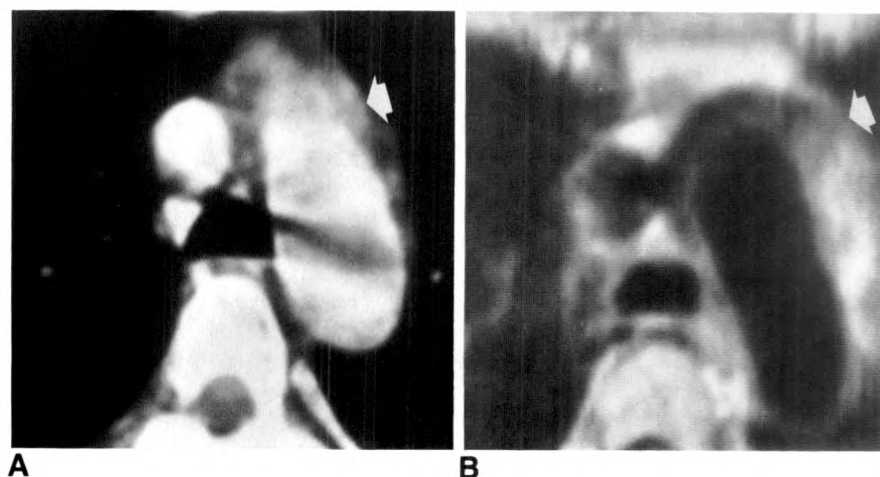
Case 3: Thymic hyperplasia in 44-year-old woman with myasthenia gravis with normal thymus on CT and MR.
